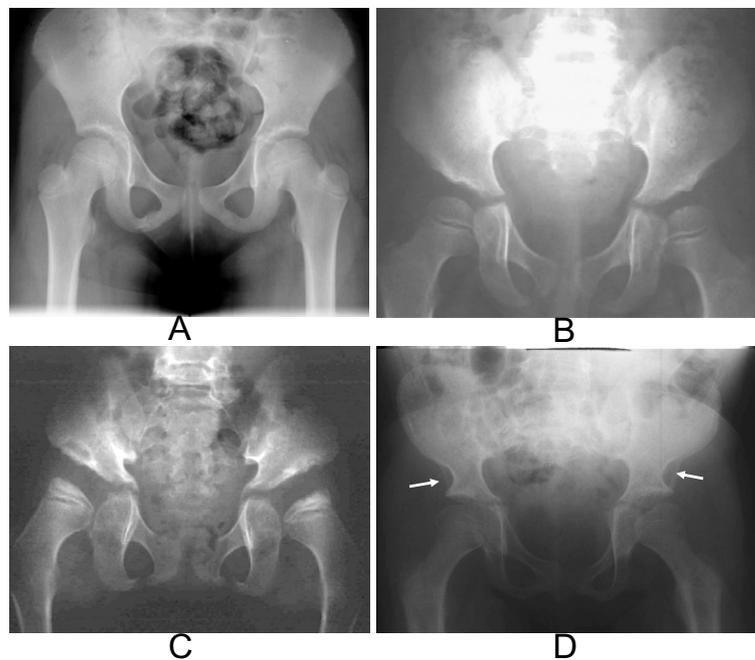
Manifestations of dysostosis multiplex in the pelvis and hips. Radiographs showing (A) normal pelvis and hips, and pelvis and hips of MPS patients with (B) rounded iliac wings and mild ileal tapering, (C) capital femoral epiphyseal dysplasia and lower iliac wing tapering, (D) rounded iliac wings, double-contoured ileal lateral walls (arrows) and elongated femoral necks.
